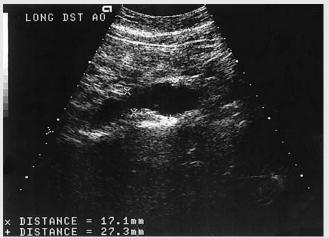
Sagittal sonogram of the distal abdominal aorta.
